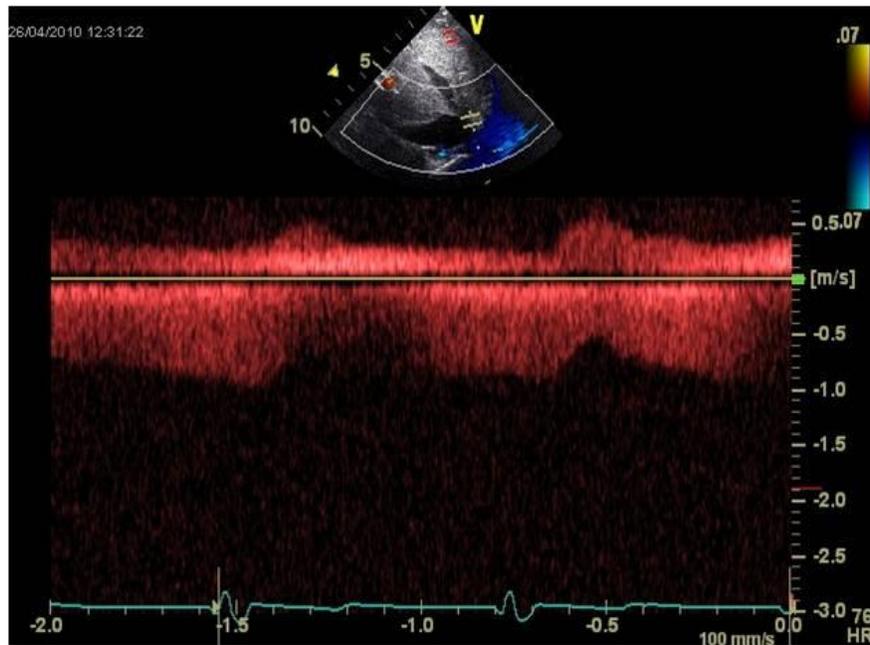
Pulsed wave Doppler interrogation of IVC in first patient showing preserved respiratory related variation of IVC flow
